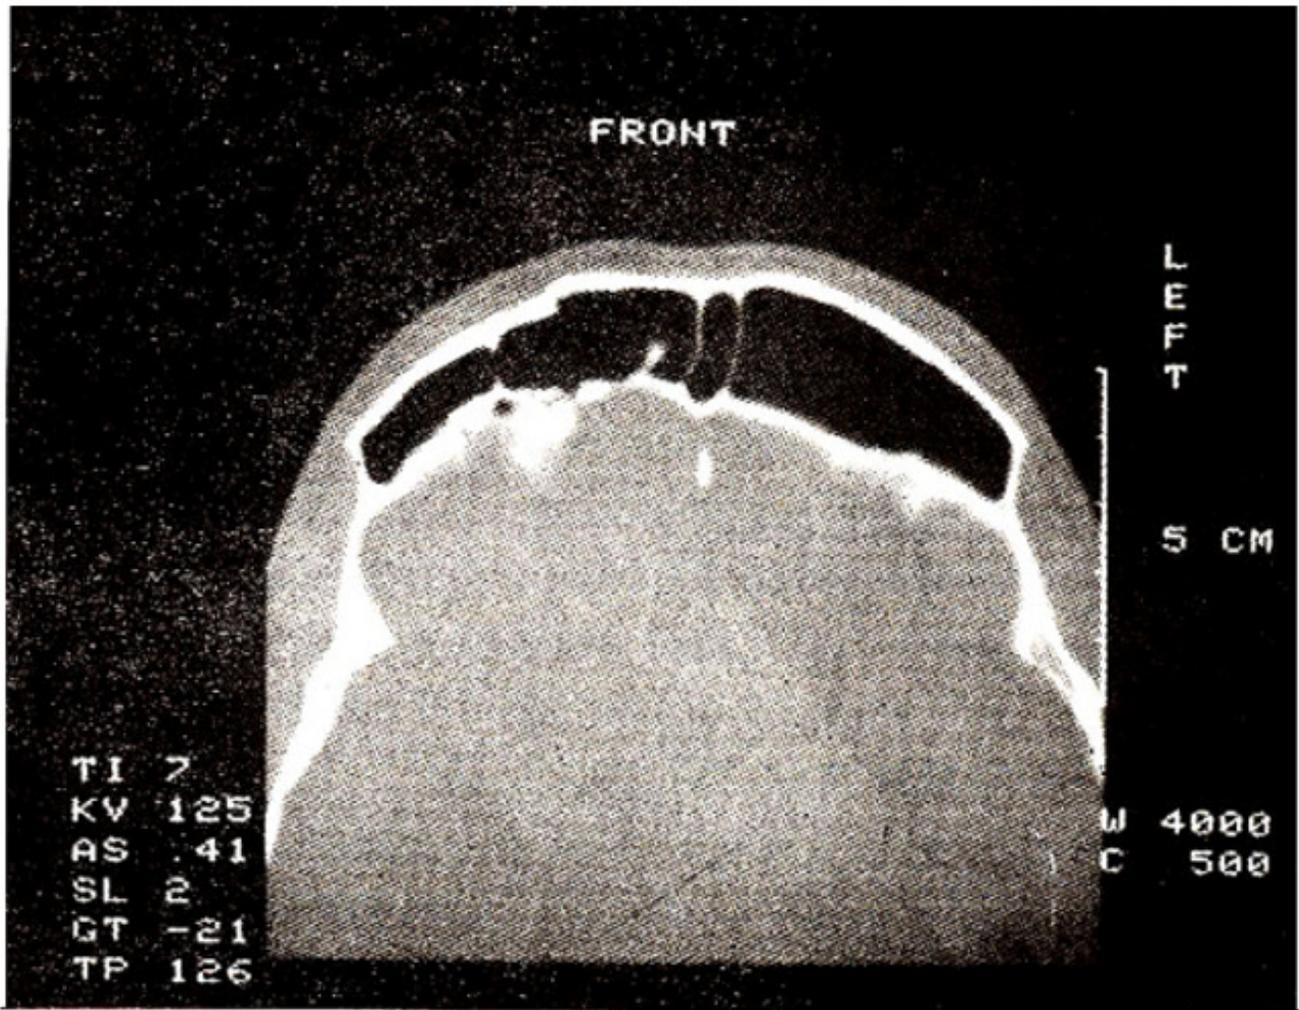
High definition axial CT scan of the head showing fractures through anterior and posterior wall of right frontal sinus.
